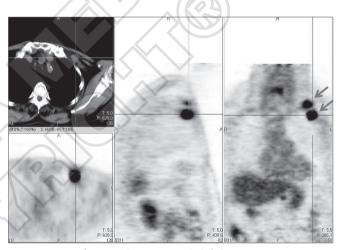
A 56-year-old woman with left breast cancer, an invasive ductal cancer, treated three years ago with surgery and radiotherapy. Three-planes images of FDG-PET/CT and one of CT (up on left) demonstrate two focal uptakes of radiopharmaceutical, one in supraclavicular left lymph node and another in the proximal homolateral clavicular. Based on PET/CT finding, patient received radiation treatment for the metastatic sites.
